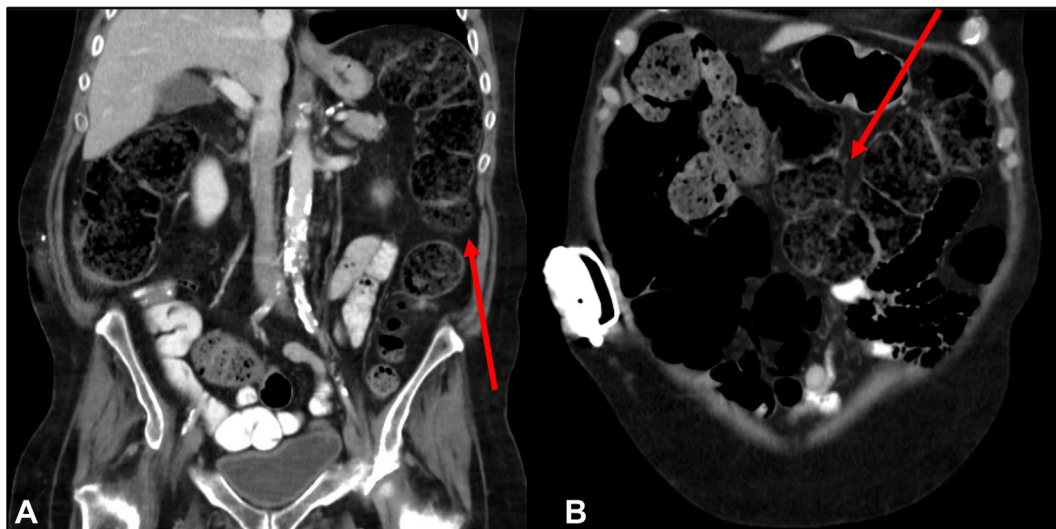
Imaging findings of a long, redundant colon. A, Coronal CT colonography showing a long (270 cm) colon with a sigmoid colon that almost reaches the upper abdomen. B, The redundant colon takes a tortuous path throughout the abdomen.
